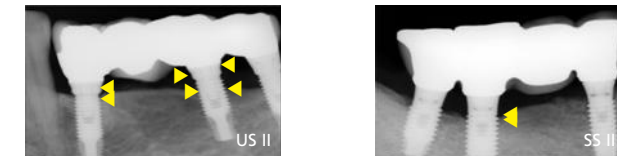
Radiographic finding of marginal bone resorption
